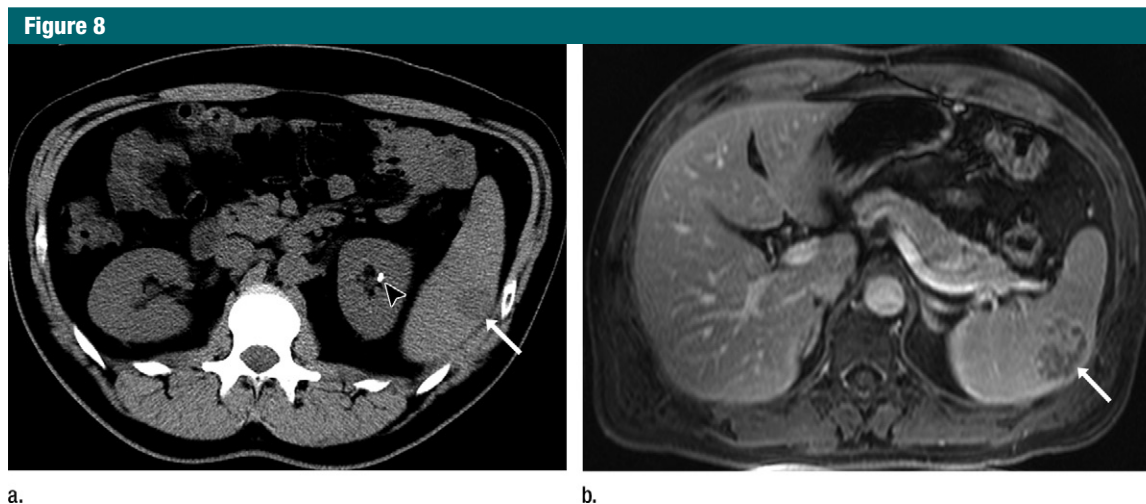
Images in a 43-year-old man for evaluation of renal calculi. (a) Unenhanced axial CT image demonstrates renal calculus (arrowhead) and splenic mass (arrow). MR imaging was recommended for follow-up of splenic mass and was performed 7 months later. (b) Intravenous gadolinium-enhanced volumetric interpolated breath-hold examination, or VIBE, delayed-phase image demonstrates heterogeneous enhancement in mass. Because of rapid increase in size (1 cm over 7 months, from 2.6 to 3.6 cm), patient underwent splenectomy, which revealed a sclerosing angiomatoid nodular transformation.
